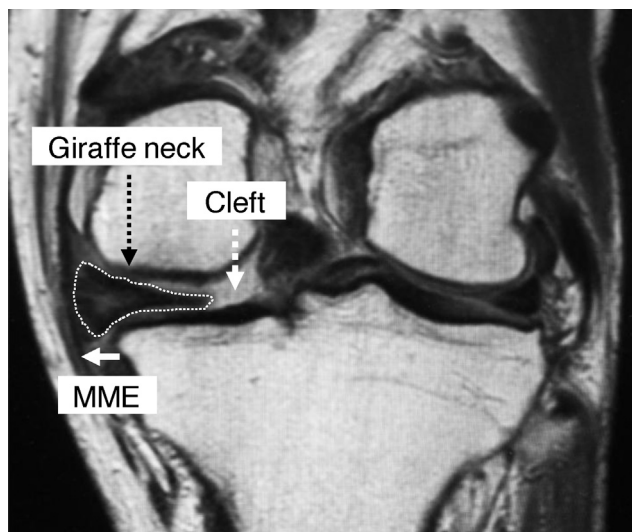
Characteristic signs of the MMPRT on MR images. A 60-year-old woman (the left knee). Giraffe neck sign of the MM posterior segment (dotted area and dotted black arrow). Cleft sign (dotted white arrow). Medial extrusion of the MM (MME, arrow).
